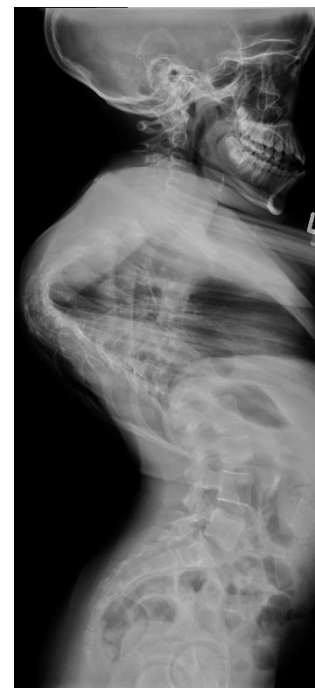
Pre-operative lateral x-ray in congenital scoliosis
